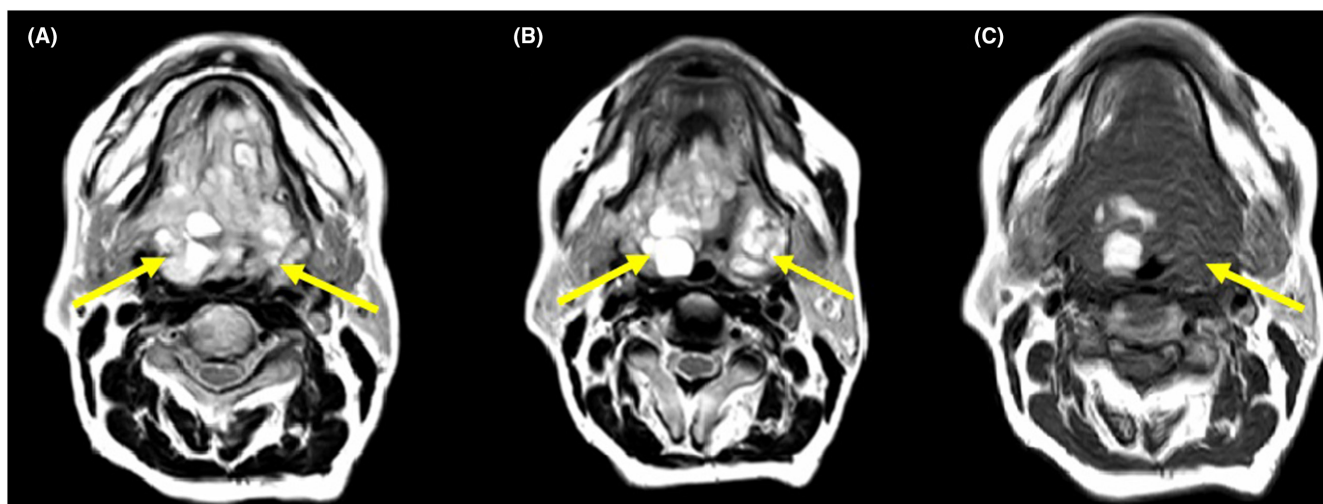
Axial images of pre-treatment head and neck MRI. (A and B) T1-weighted sequence with gadolinium contrast showing a large and multilobulated lesion in the base of the tongue involving central part of the tongue and sublingual space (yellow arrow). (C) T2-weighted sequence showing large and loculated mass (yellow arrow).
